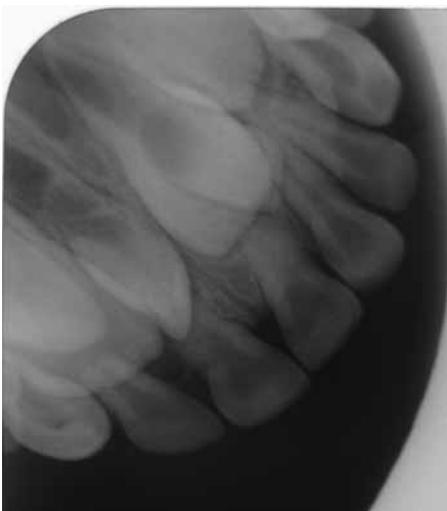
An upper anterior occlusal radiograph also showing the presence of a supplemental tooth for the same patient as in Figure 1.
